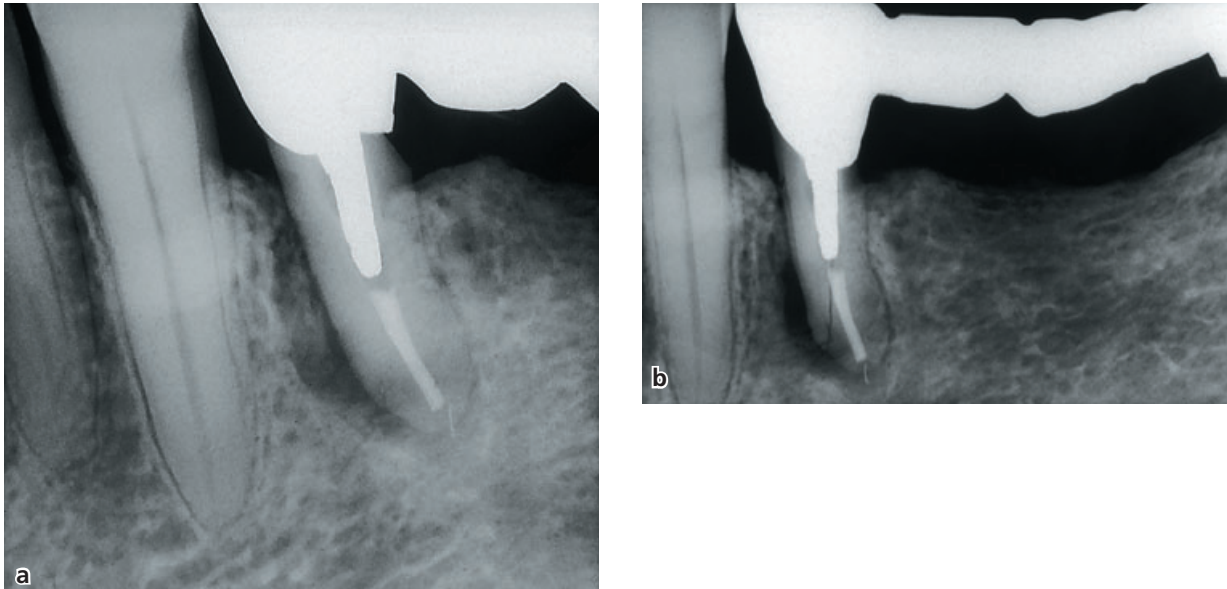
(a) Mandibular premolar included in a four-unit bridge showing a bone lesion at the mesial aspect of the root. In this projection there is no sign of fracture, while in a radiograph (b) taken with a slight shift of angle, a fracture line is clearly visible. Case kindly provided by Dr. K-G. Olsson.
